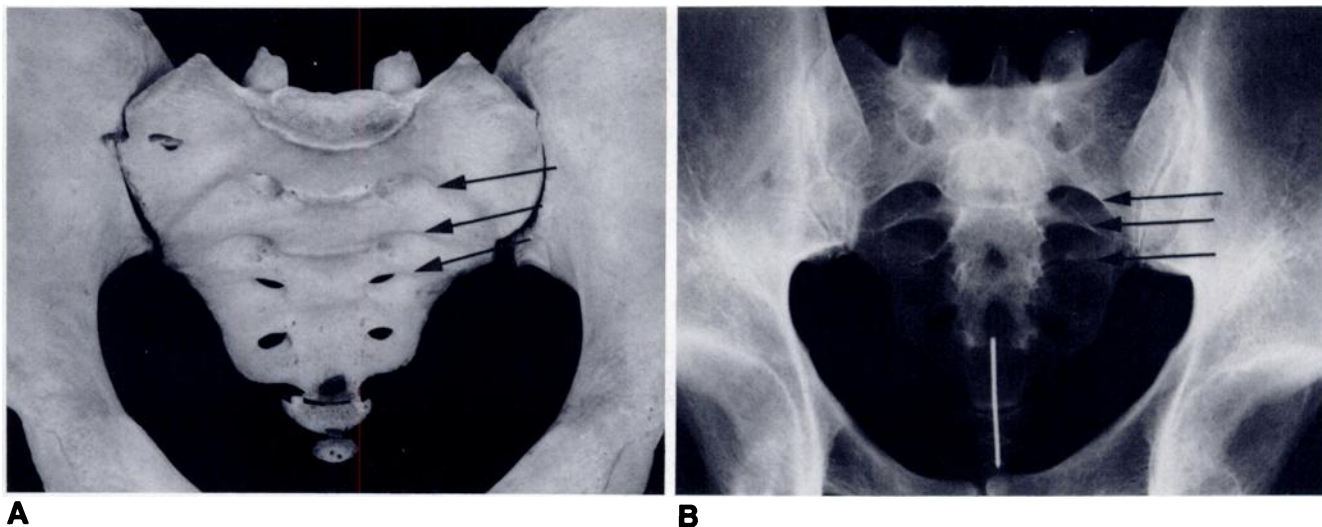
Photograph (A) and anteroposterior radiograph (B) of detached bony pelvis. Normal sacral arcuate lines exhibit left-right symmetry (arrows indicate three lines on left).
